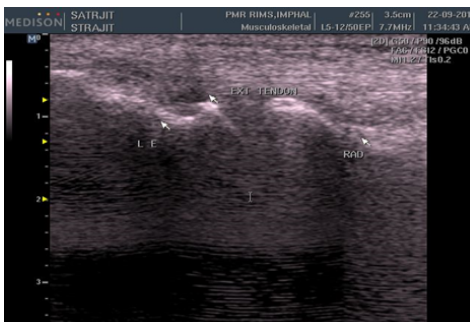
Ultrasound image of lateral epicondyle
